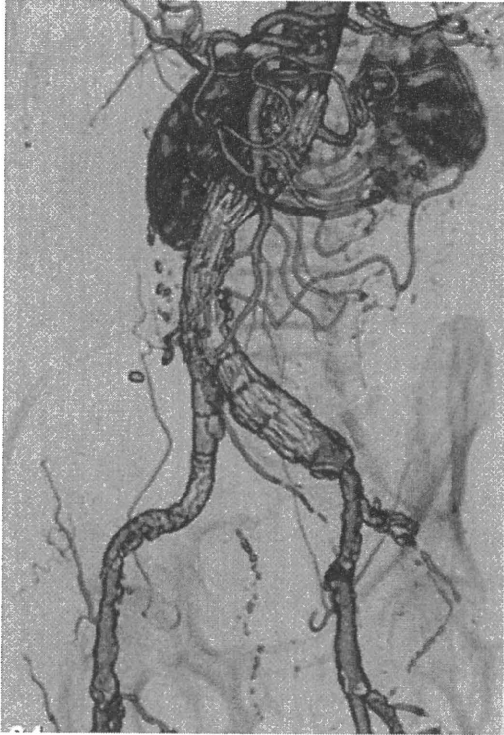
Postoperative 3D-CT demonstrated patent blood flow of the right graft limb
